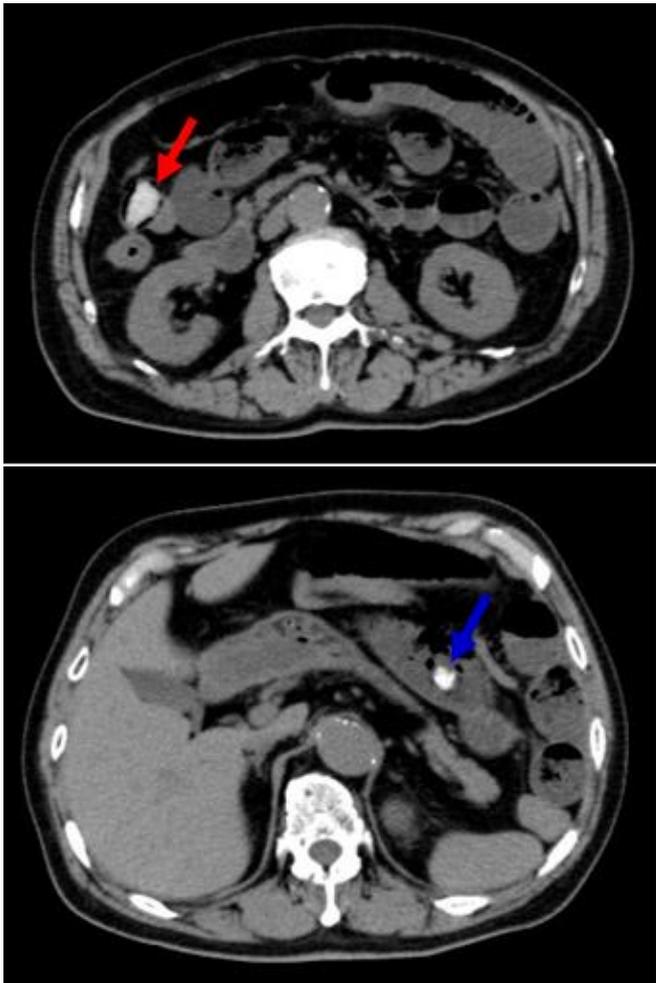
Abdominal CT showing two high-density lesions. 1a: SBO by rice cake in the right middle abdomen (red arrow); 1b: SBO by rice cake in the left upper abdomen (blue arrow).
